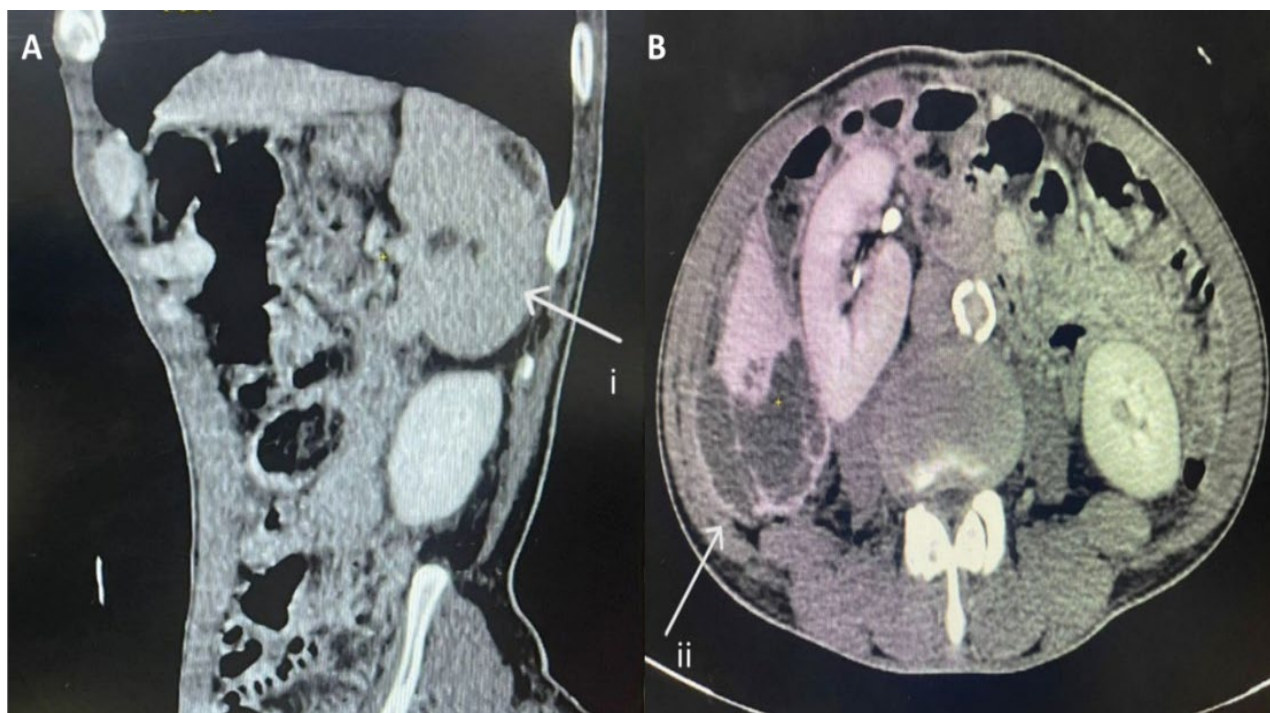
A) Longitudinal section of the CT - Abdomen showing abscess in spleen (white arrow i); B) Cross-section of CT abdomen showing abscess in liver (white arrow ii).
